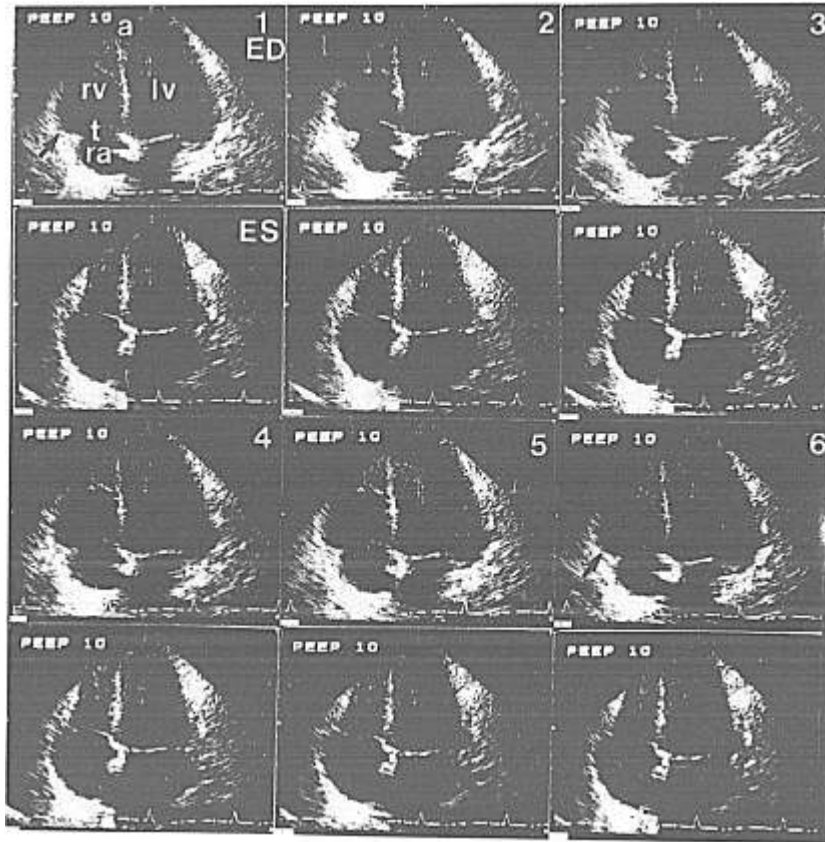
An example of beat by beat two-dimensional echocardiographic examination at end-diastole (top) and end-systole (bottom). Beats 1 to 4 occurred during expiration and beats 5 and 6 occurred during inspiration: rv = right ventricle; ra = right atrium; t = tricuspid valve; lv = left ventricle; a = apex. The largest RV cavity (arrow) is observed at beats 1 and 6.
